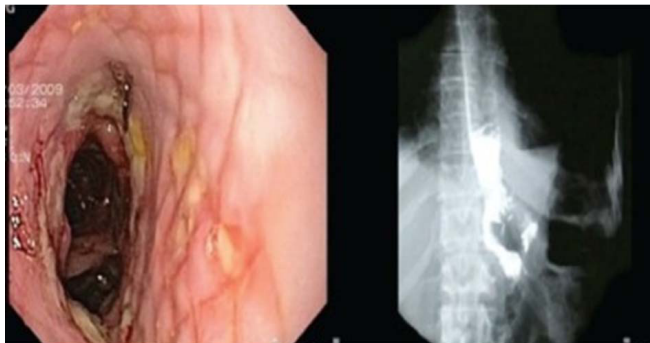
C-CEMS removal, & Healed leak site on radiography
